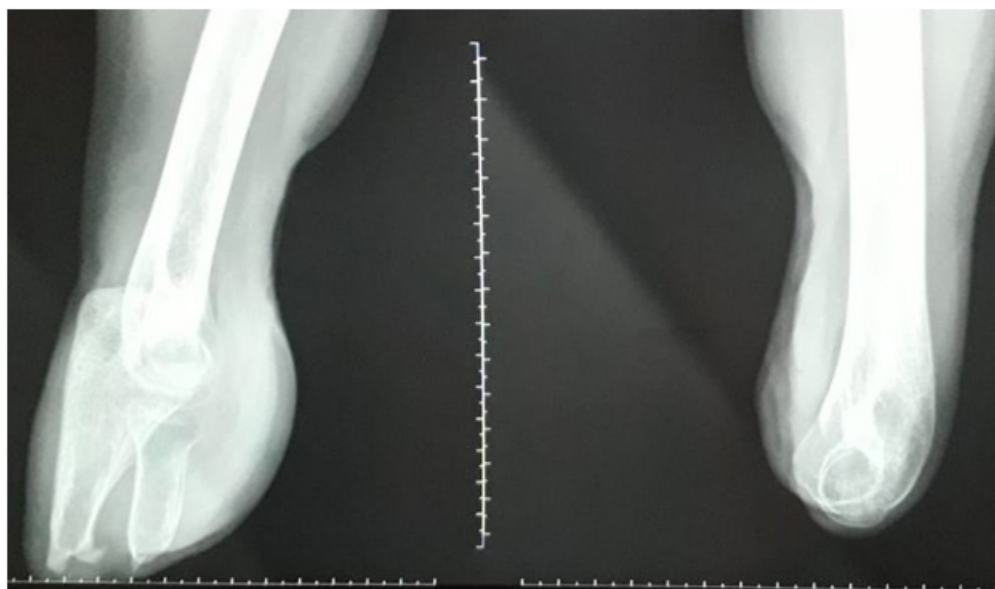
X-ray of the stumps of the right forearm in the upper third and the stump of the left shoulder after exarticulation in the elbow joint. Osteophytes of the ends of the forearm bones are visible
